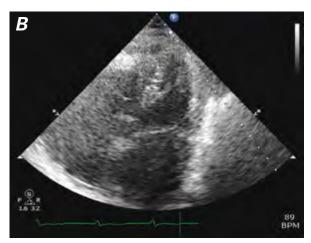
Echocardiogram (apical 4-chamber view) 20 days after cardioversion shows resolution of apical ballooning and normal left ventricular ejection fraction in A) diastole and B) systole.
